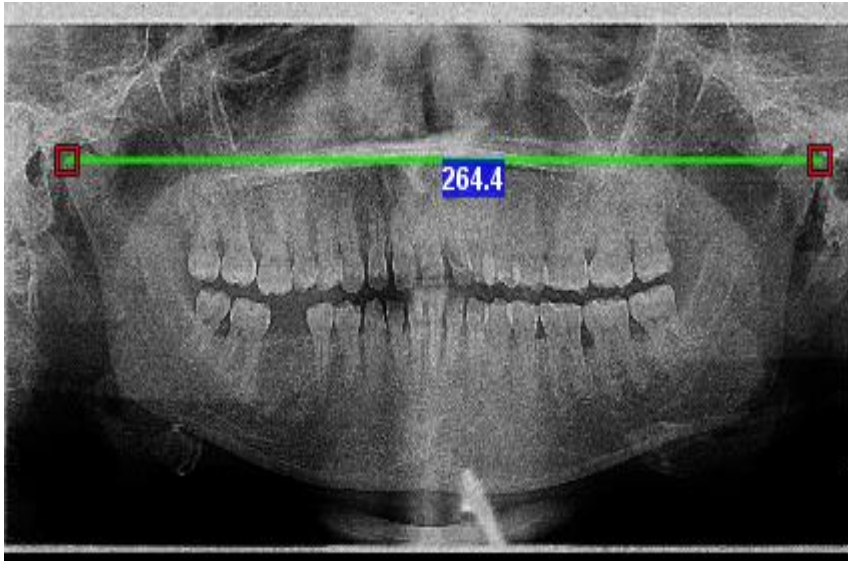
Measurement of bicondylar breadth in an orthopantomogram
